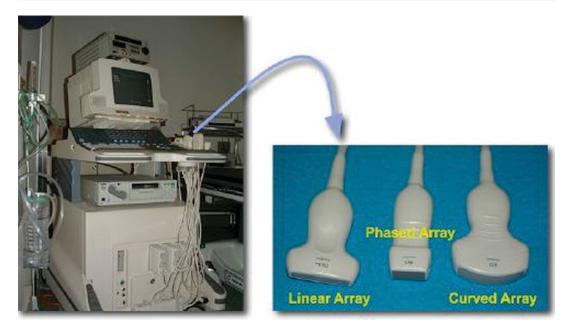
Ultrasound transducers (Image Licensing Wikimedia Commons; Public Domain) [10] (Reprinted from USMachTxPhoto, Wikimedia Commons. KieranMaher.
